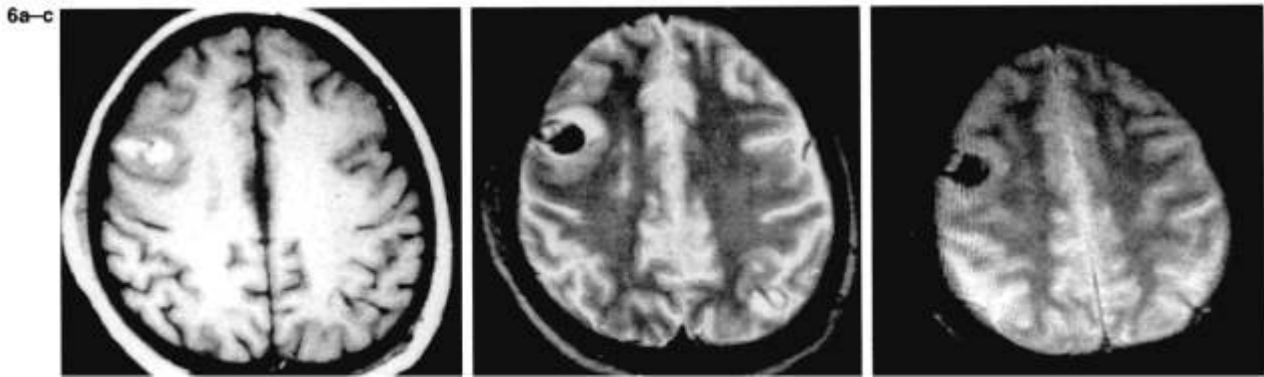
Four and one-half day superficial hematoma (related to traumatic shunt removal) at 1.5 T. Surrounding edema is present in all images. a: In T1-weighted image (TR 600/TE 15 ms), blood is hyperintense because of enhanced relaxation caused by paramagnetic methemoglobin (metHb). b: In T2-weighted image (TE 2,500/TE 80 ms), blood is hypointense owing to combination of inhomogeneous susceptibility and paramagnetic relaxation with metHb. c: In T2*-weighted image (FISP, TR 200/TE 10 ms, flip angle = 10°), blood also shows strong hypointensity because of inhomogeneous susceptibility effect.
